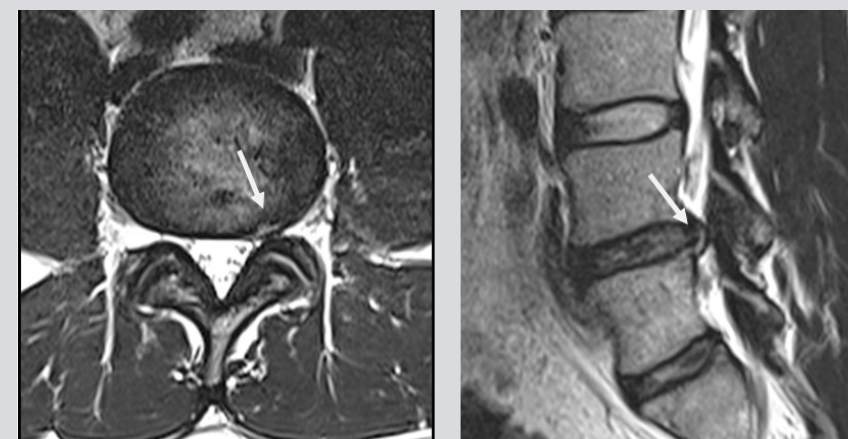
T2-weighted MRI images, axial on the left, sagittal on the right. This shows grade IV discopathy at L4/5 and 5/S1 on the modified Pfirrmann scale. There was also a high-intensity zone (HIZ) representing a fissure/tear in the posterior annulus at L4/5 (see arrow). High intensity zones are a phenotype that shows as a hyperintense area of the intervertebral disc in a T2-weighted MRI and which has been described as a potential imaging biomarker for identifying symptomatic intervertebral discs.
